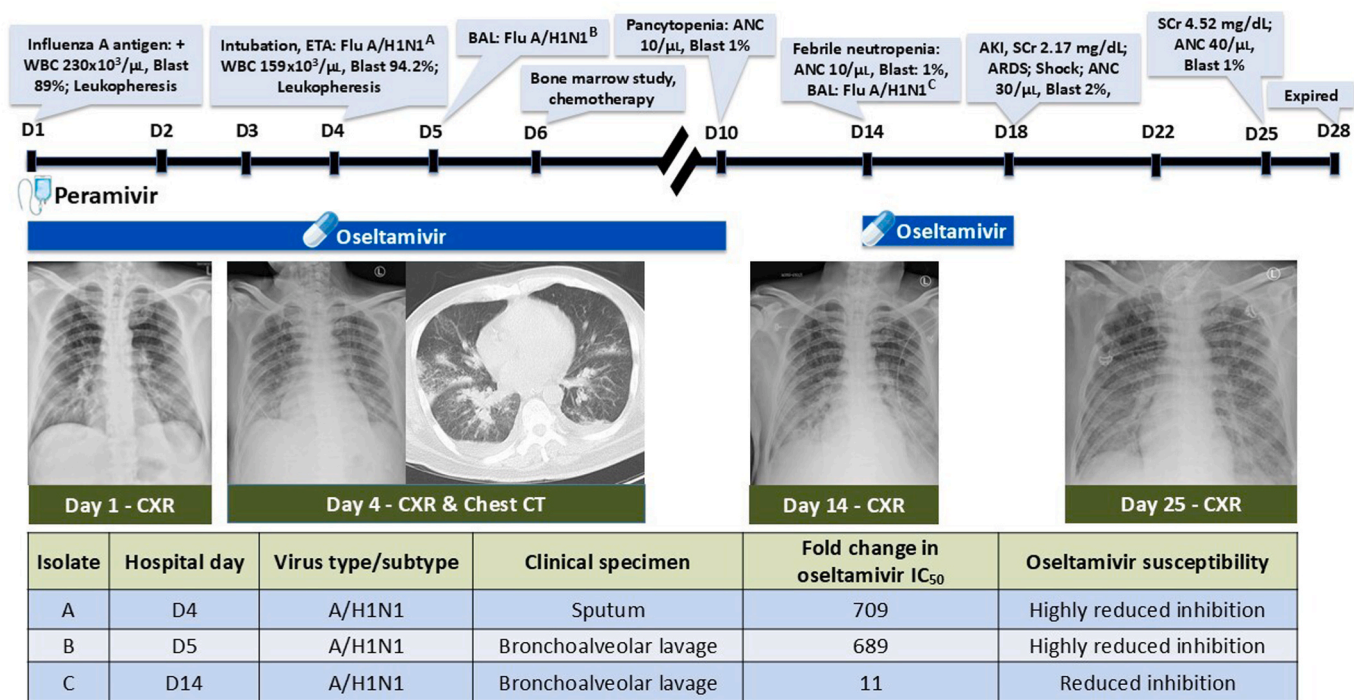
Hospital course of an immunocompromised patient with bilateral pneumonia due to oseltamivir-resistant influenza A/H1N1 virus. Note: WBC: white blood cell; ETA: endotracheal aspirate; BAL: bronchoalveolar lavage; Flu: Influenza; ANC: Absolute neutrophil count; AKI: acute kidney injury; SCr, serum creatinine; ARDS: acute respiratory distress syndrome; CXR: chest X-ray; CT: computed tomography; IC₅₀: half maximal inhibitory concentration.
